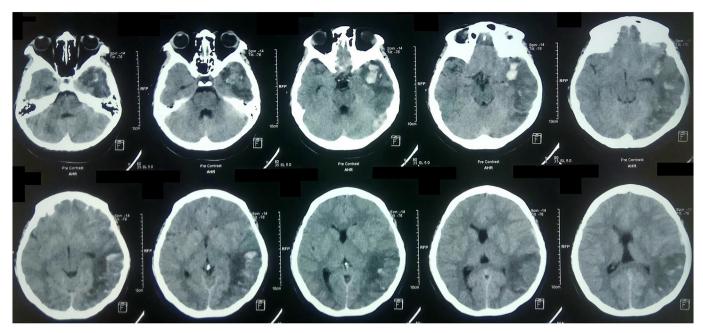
The patient was misled by hemorrhage lesion because of CT Scan shown multiple hyperdense mass at temporoparietal.
